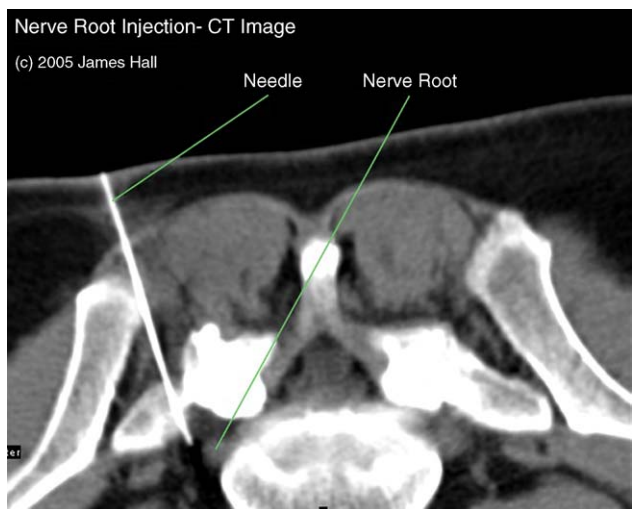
CT image of spinal needle placed within a centimeter of nerve root to inject mixture of local anesthetic and corticosteroid medications.
